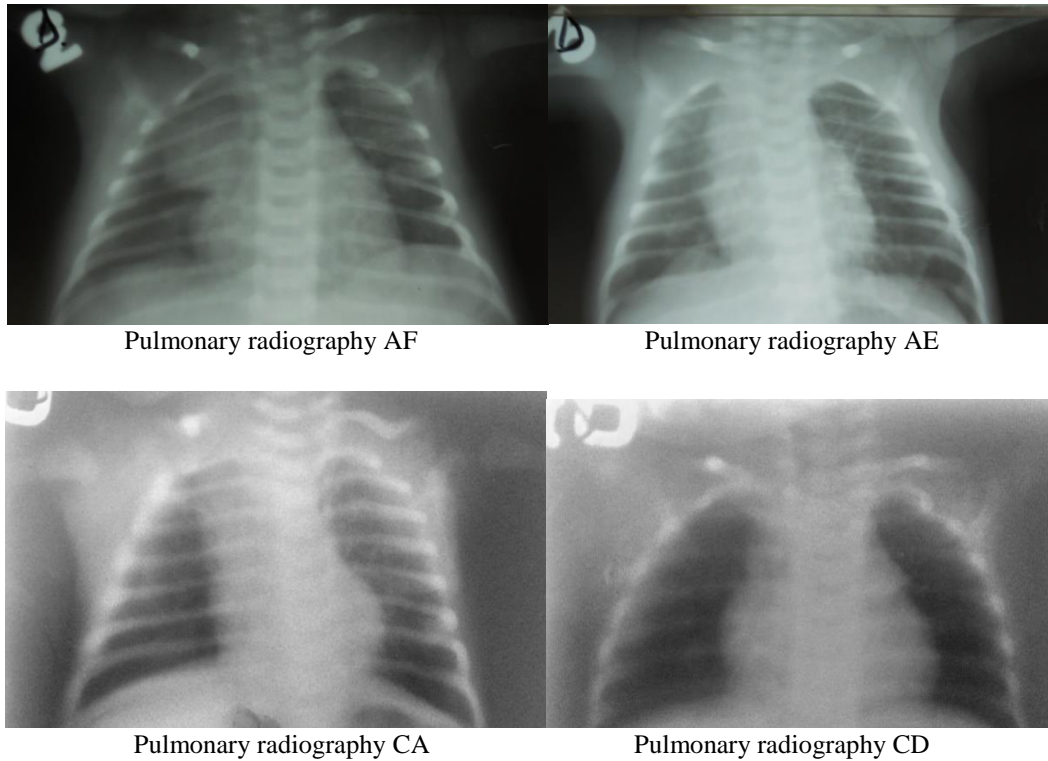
Thymus hypertrophy on all 4 radiographs
